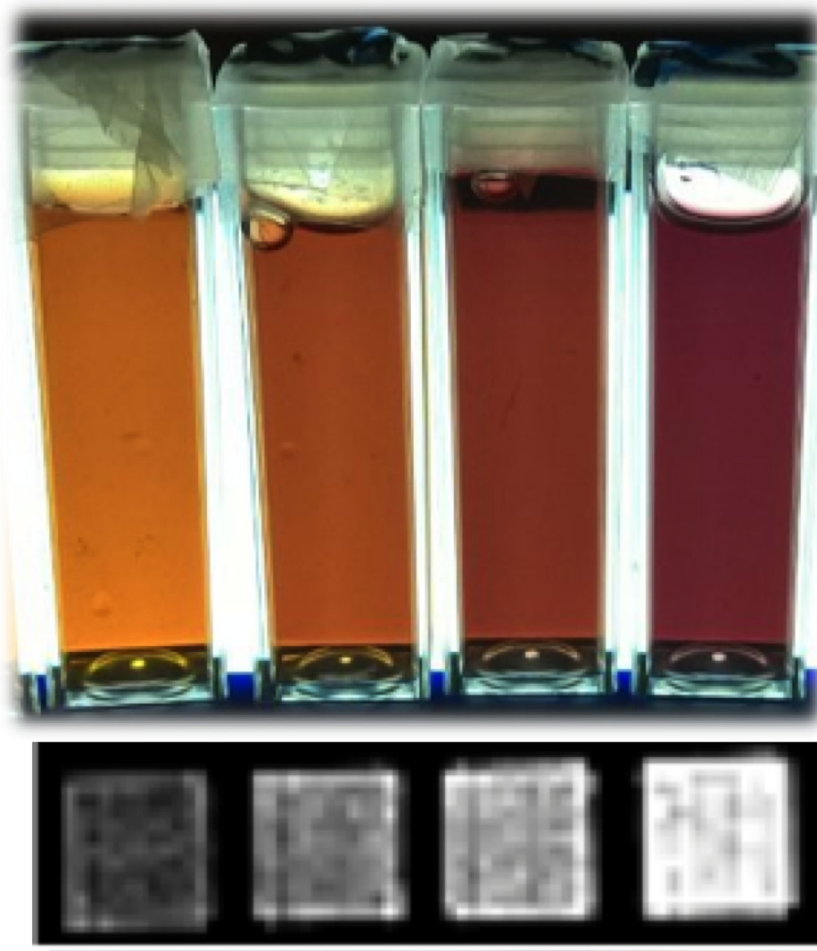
Photograph and T_1 -weighted 0.3 T MRI maps of Fricke-XO GTA-PVA gel cuvettes (1 cm side) irradiated to increasing absorbed doses.
